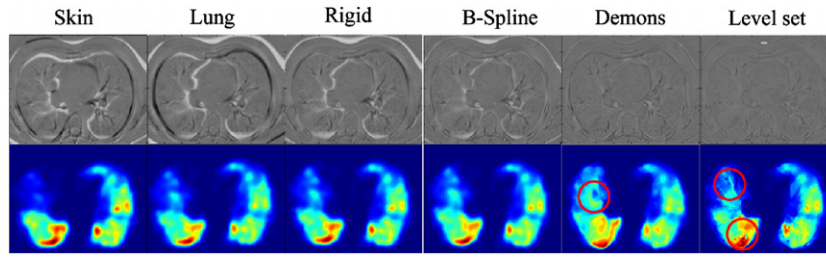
Above: slices of the difference image computed between the *moving CT image* and the *fixed CT image* after each registration. Below: slices of the SPECT images warped with the deformation field from each registration. Circles indicated where SPECT signals are clinically invalid.
